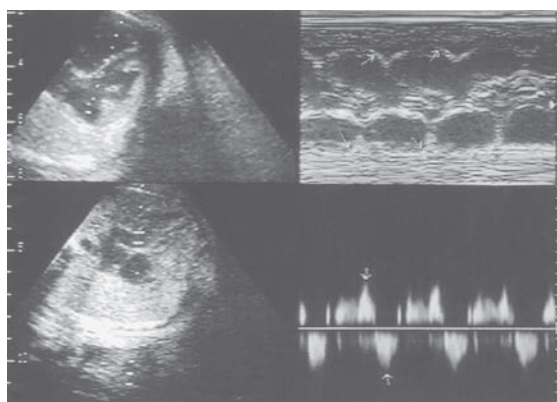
Two-D and M-mode tracing of the fetal heart (upper figures): The beam passes through the right ventricle and the left atrium. Ventricular (upward arrows) and atrial (downward arrows) contractions are synchronized and fetal heart rate is 94 beat/min. The pulsed Doppler interrogation (lower figures) in the left ventricular outflow tract demonstrates synchronized atrial (upward arrow indicates A wave) and ventricular (downward arrow) contractions.
